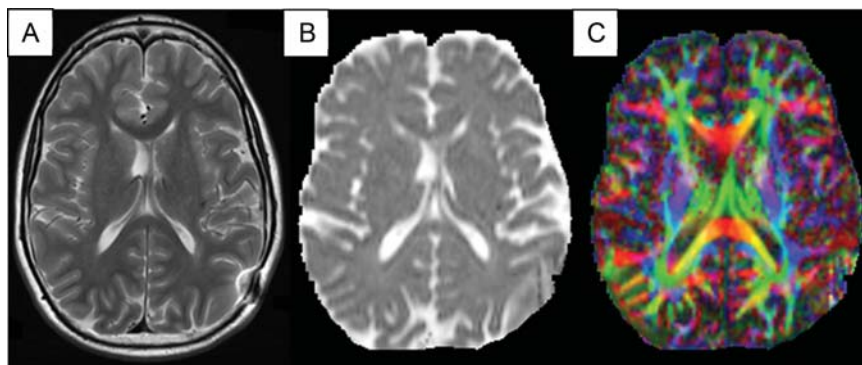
DTI for one MB patient. (A) T2-weighted image, axial slice. (B) Apparent diffusion coefficient map without directional information. (C) Fractional anisotropy directional map. Red: left-right; green: anteroposterior; blue: superior-inferior.
